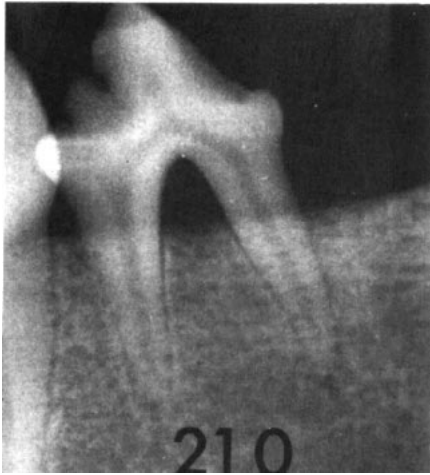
Radiographic appearance of one lower premolar region after 210 days of experiment.
